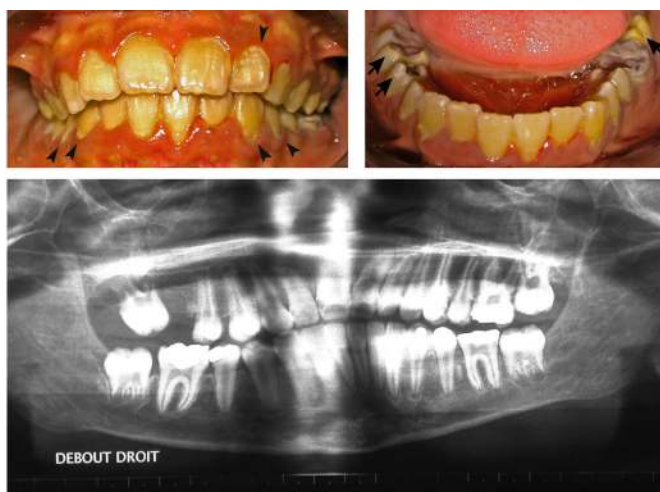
Intraoral photographs of case 1. Of note, all teeth are green with areas of hypomineralisation. (A) Frontal view: teeth show a yellow-green discolouration. Plaque and debris are noted (arrowheads). Gingival inflammation and bleeding are also present. (B) Mandibular view: areas of hypomineralisation are present on the labial cusps of #18, #29 and #30 (long black arrows). (C) Orthopantomogram: all permanent teeth are present except #3 and wisdom teeth.
